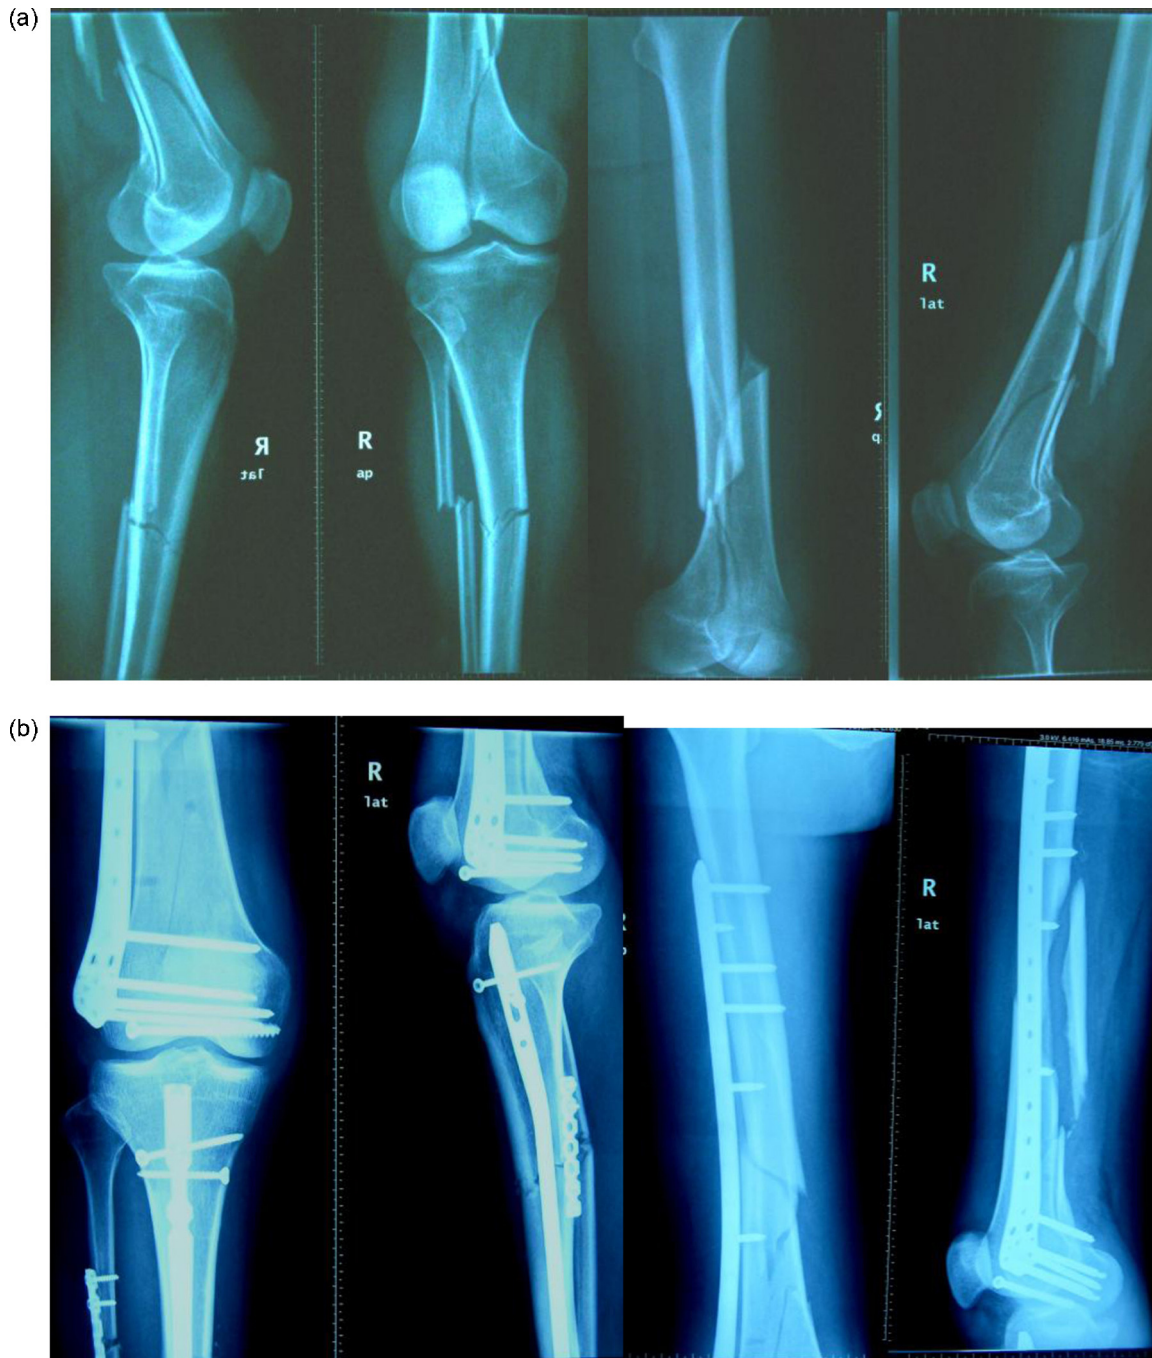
A 48-year-old patient sustained a type IIA (articular simple) floating knee. A single incision was used for stabilisation of both fractures. The LISS was used for the fixation of femur fracture and UTN (unreamed tibia nail) for tibia fracture. (a) Radiographs before surgery. (b) Radiographs immediately after surgery. Close reduction technique was used for both shaft fractures. Note the posterior fragment in the femur shaft was untouched during surgery. (c) Radiographs 6 months postoperatively demonstrated bridging callus. (d) The patient had an excellent result.
